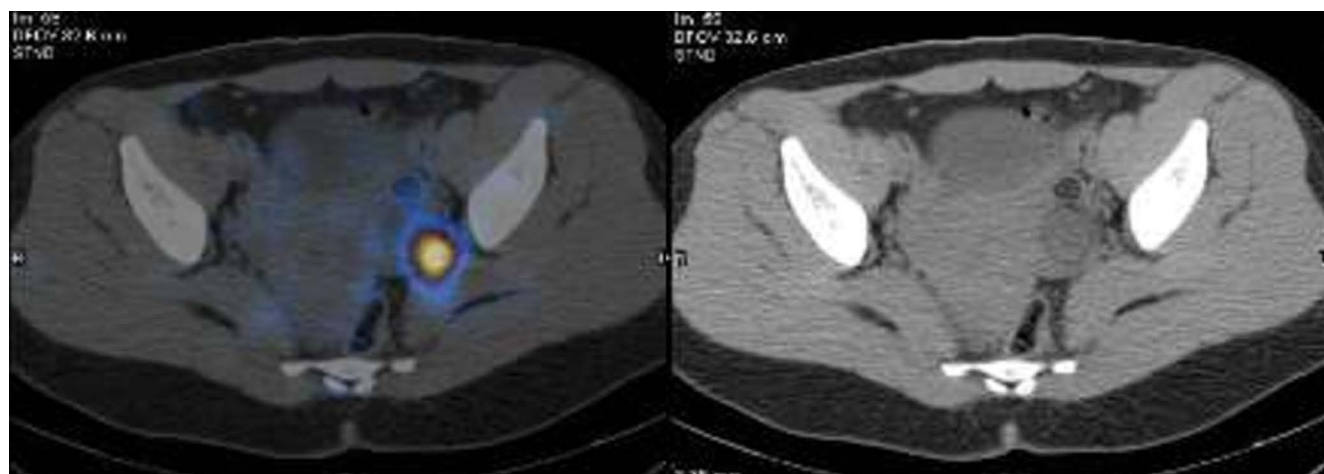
SPECT/CT images revealed a focal zone of iodine uptake on the left side of the pelvic cavity, corresponding to the well-defined heterogeneous mass (5 × 6 cm), which was containing fat, fluid, and amorphous calcification in the left ovary in the CT slices
